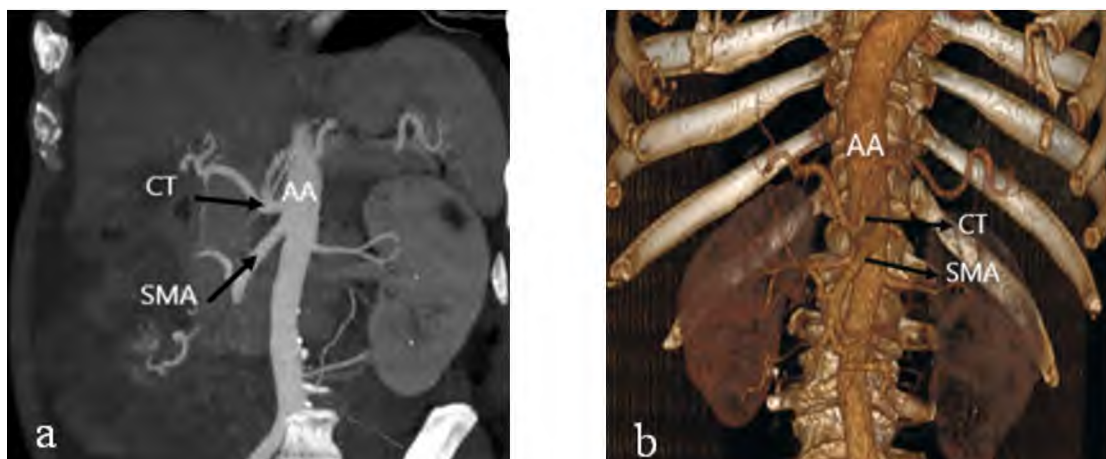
(A) Maximum intensity projection (MIP) coronal image and (B) Volume rendered image of a male patient aged 34 years showing normal anatomy of Celiac Trunk (CT) and Superior Mesenteric Artery (SMA) arising together from the Abdominal Aorta (AA). Uflacker Type I.
